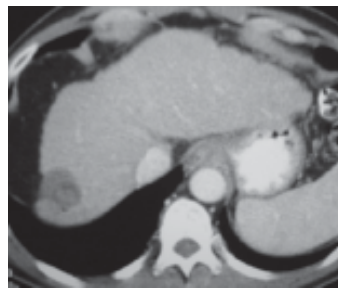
Follow up CT shows lack of enhancement in the lesion
